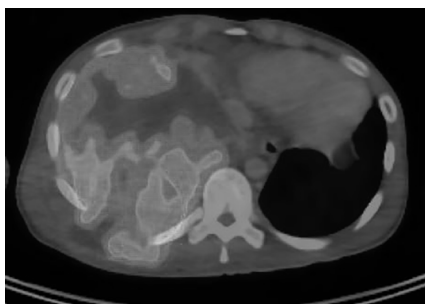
PET-CT study showing increased metabolic activity in the dominant solid component in the posterior aspect in keeping with a tumour, as well as pleural metastases anteriorly. PET-CT: positron emission tomography-computed tomography
